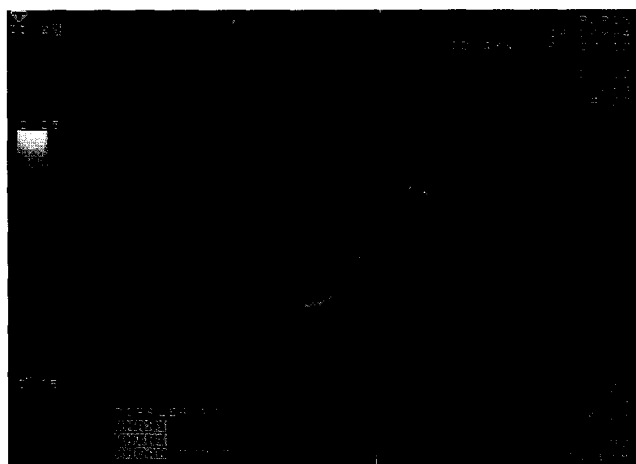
Color Doppler imaging at the level of the placental bed, demonstrating the vascular nature of the echo-poor areas detected under the placenta during the gray-scale ultrasound examination
